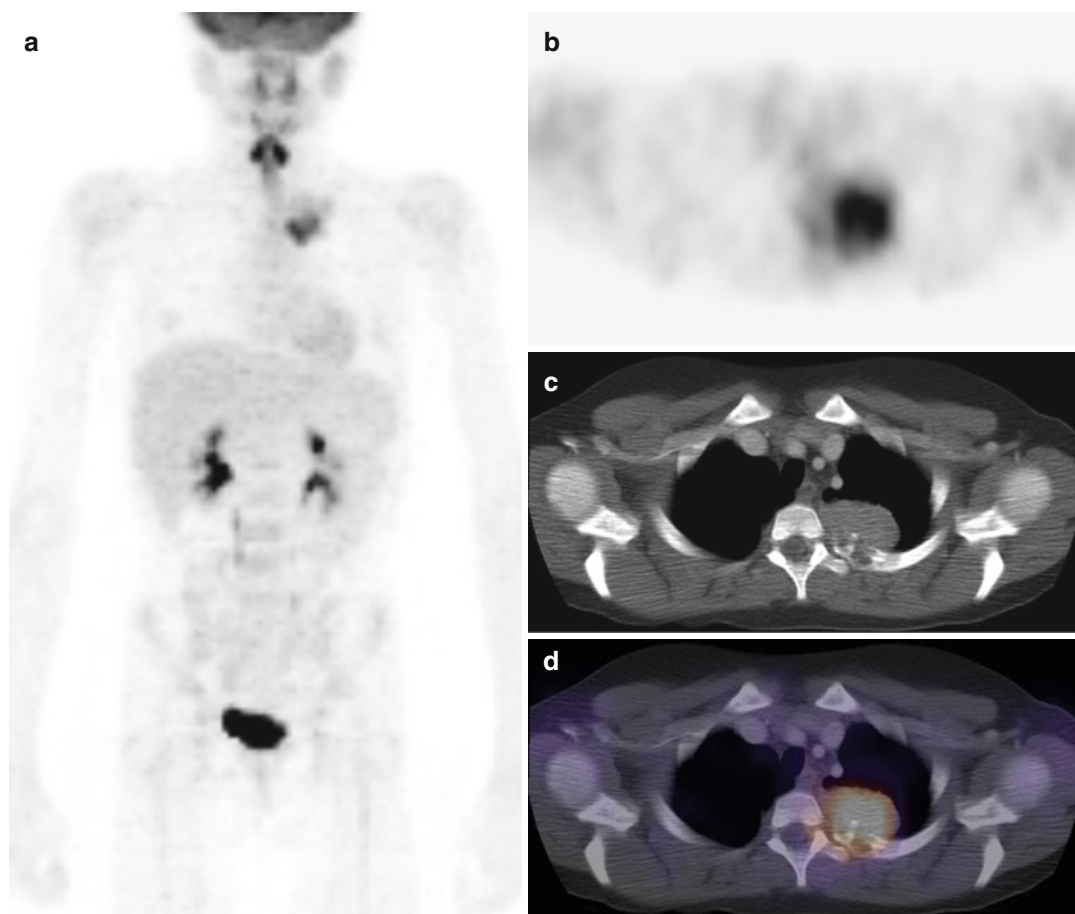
Fluorine-18-FDG PET, bone scan, and contrast-enhanced CT for the evaluation of Ewing sarcoma of the chest in a 13-year-old girl with back pain. (a) The MIP of the ^{18}F -FDG PET demonstrates heterogeneous uptake in the upper left back, corresponding to the site of pain. No other sites of abnormal ^{18}F -FDG uptake are identified. (b) In the transaxial plane, abnormal ^{18}F -FDG uptake is seen in the posterior left chest. (c) A diagnostic CT shows a heterogeneously enhancing paravertebral mass that involves the left third rib and extends into the chest cavity and the spinal canal. (d) Co-registration of PET and CT images
